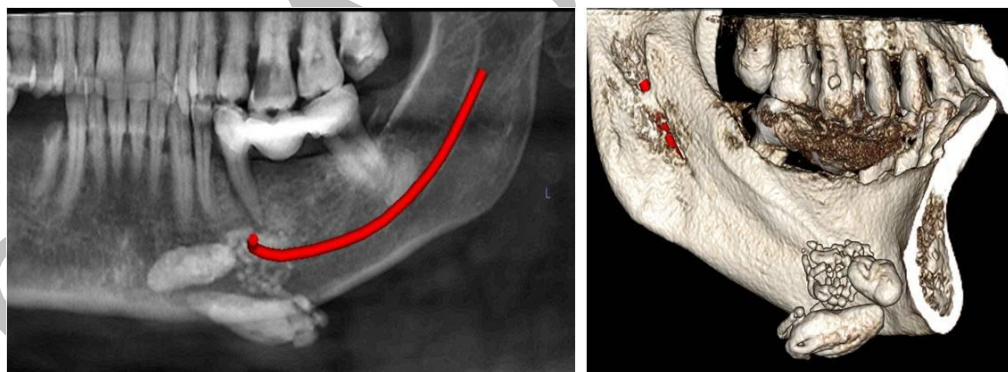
CBCT showed multiple, well defined radiopacities mesial to the mandible on left side.
